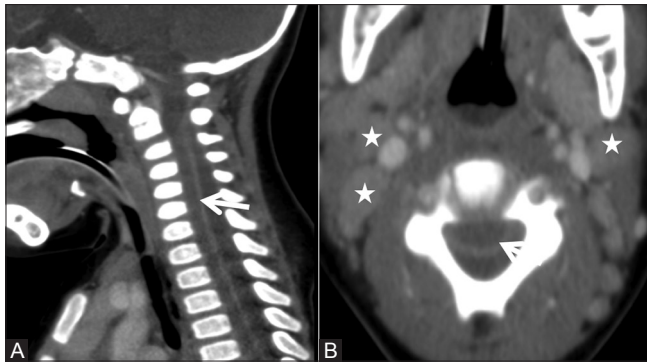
(A and B): Infective: Pyogenic abscess: Sagittal (A) and axial (B) Computed tomography scan showing hypodense fluid collection in the posterior epidural space with compression of cord anteriorly. Thick enhancing dura is also seen (arrow). Few enlarged cervical nodes are seen (asterisk)
